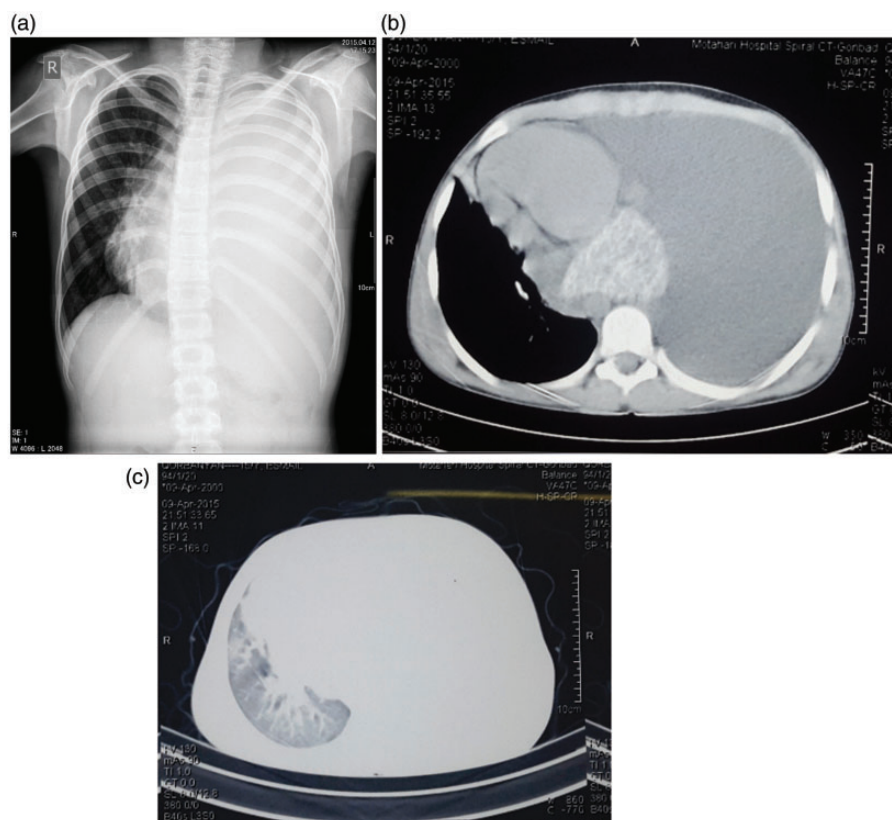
(a) Chest radiograph, (b) conventional computed tomography (mediastinal view), and (c) high-resolution computed tomography (parenchymal view) before chest tube insertion.
